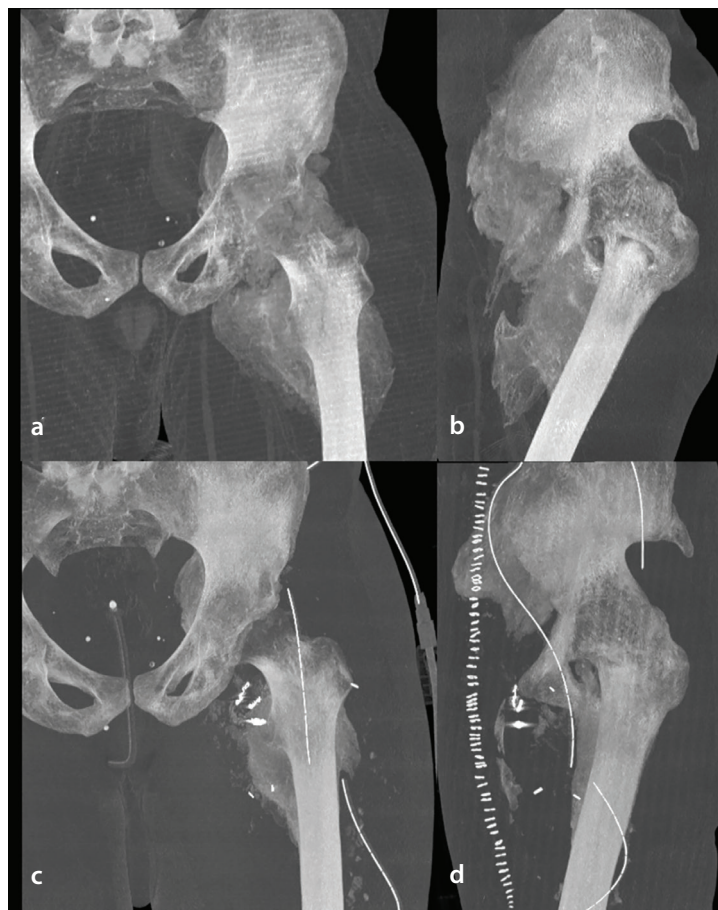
Pre-operative (a, b) and postoperative (c, d) computed tomography scan of the left hip in the maximum-intensity projection.
